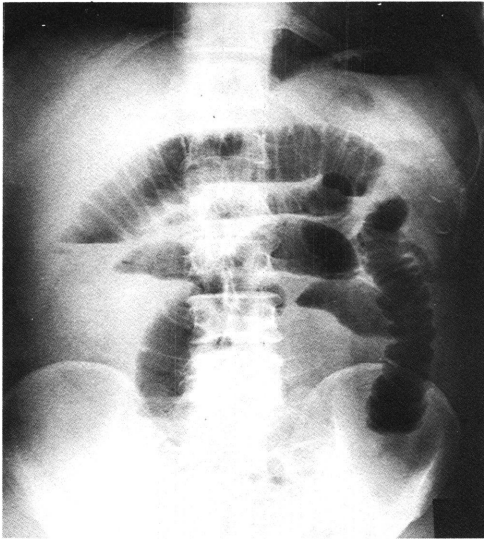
The abdominal plain x-ray on admission.
